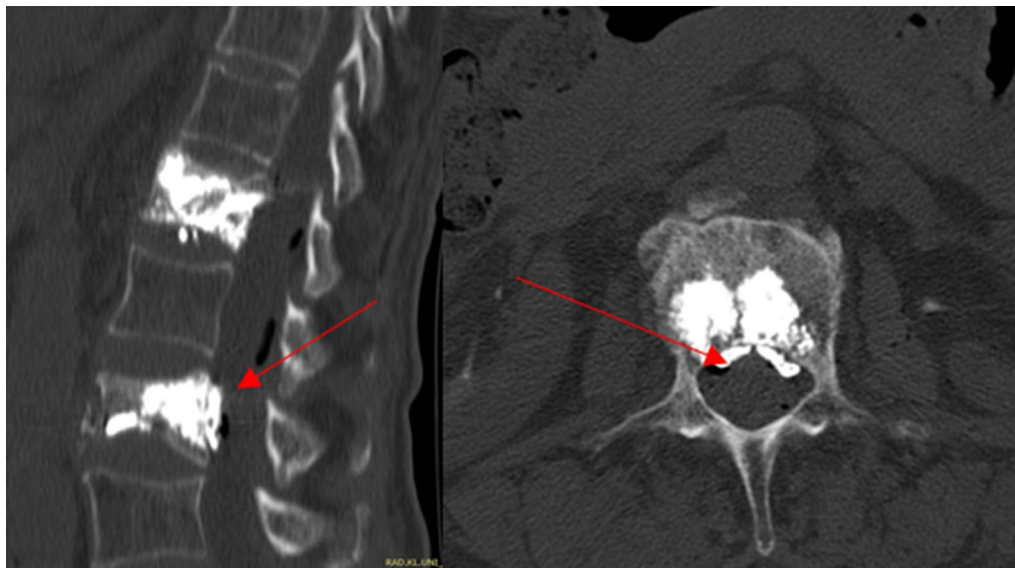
Postoperative CT scan showing complications consisting of cement extravasation (intraspinal) without neurological deficit
